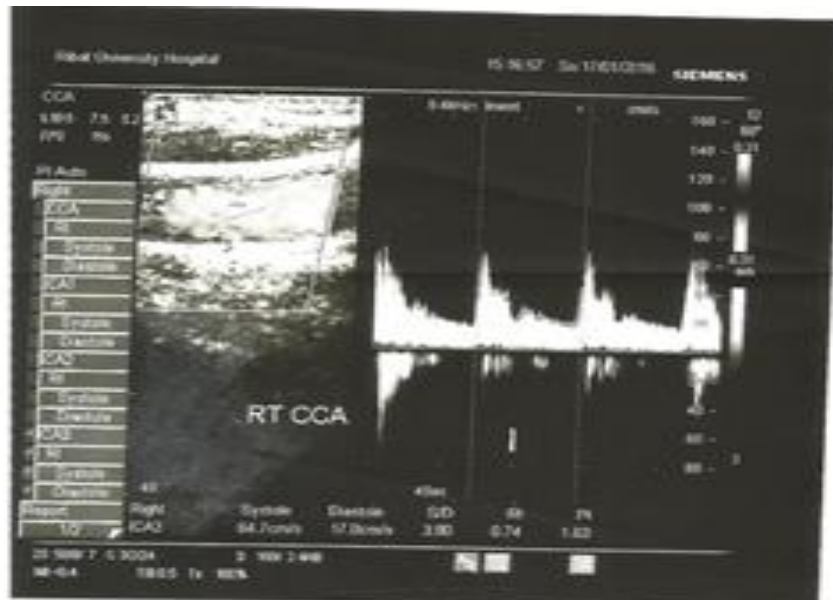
Rt ICA-male- 49 years diabetic patient with normal Doppler parameters.
